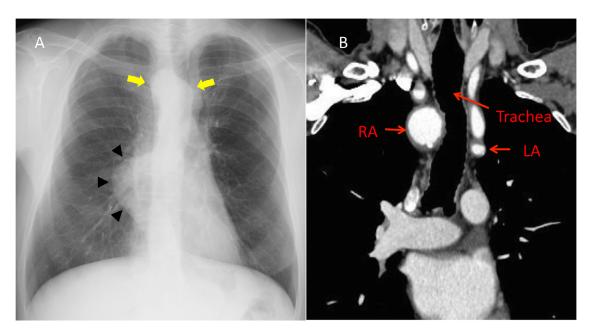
(A) Chest radiography showed the absence of a lung lesion, whereas bilateral aortic notches at the level of the aortic arch (yellow arrow), suggesting aortic arch anomaly and tortuosity of the descending aorta, projecting in to right lung (black arrow) was identified. (B) Coronal view of enhanced CT revealed separate right and left aortic arches. RA, right aortic arch; LA, left aortic arch. (Color version of figure is available online.)
